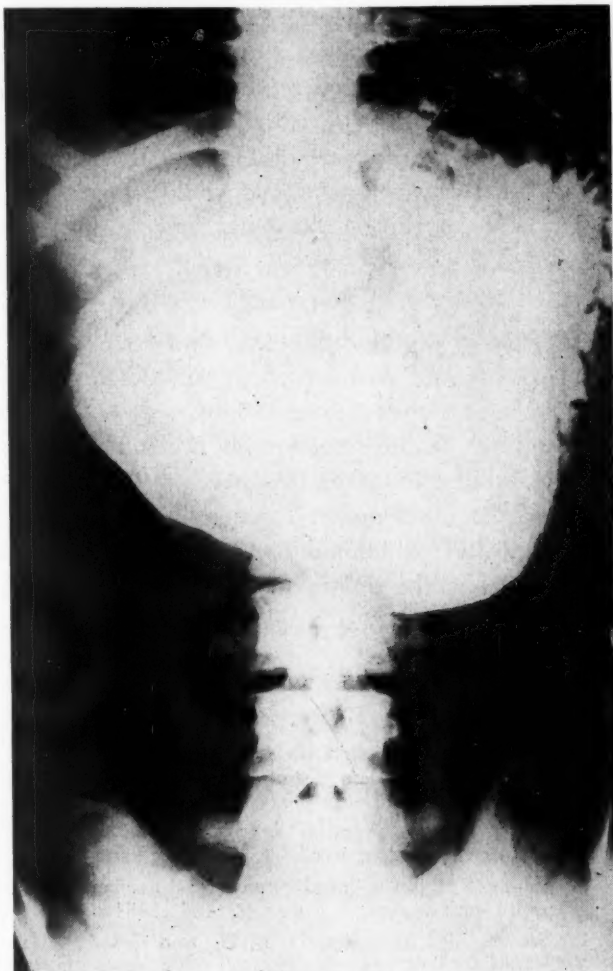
X-ray showing the dilated stomach with retention.
